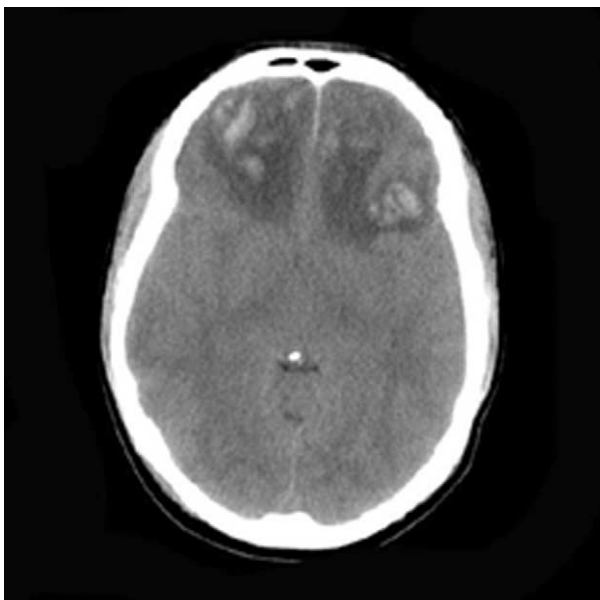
This computed tomography head scan shows bilateral frontal contusions. Note the edema surrounding the contusions as well as effacement of the normal sulcal pattern and basal cisterns.
